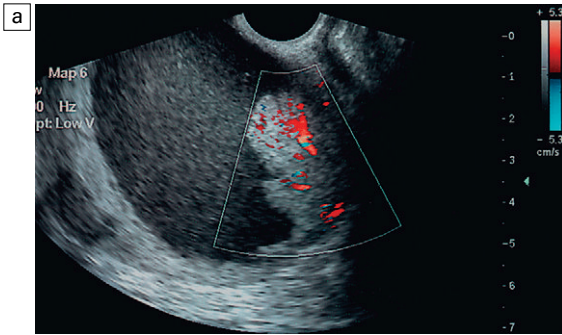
Heterogeneous ovarian mass with cystic and solid elements. Flow is demonstrated in colour within the solid component (a), and within the septum (b), although spectral Doppler, while showing low resistance, still exhibits a resistance index of greater than 0.5.
